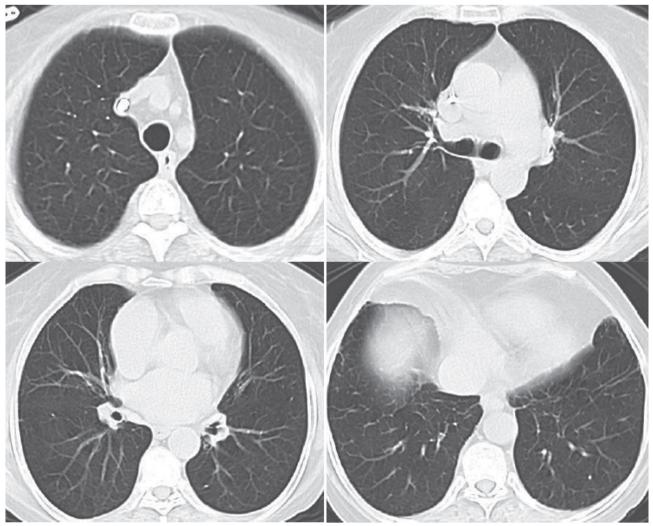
CO-RADS 1 (Normal Lung CT Scan)
